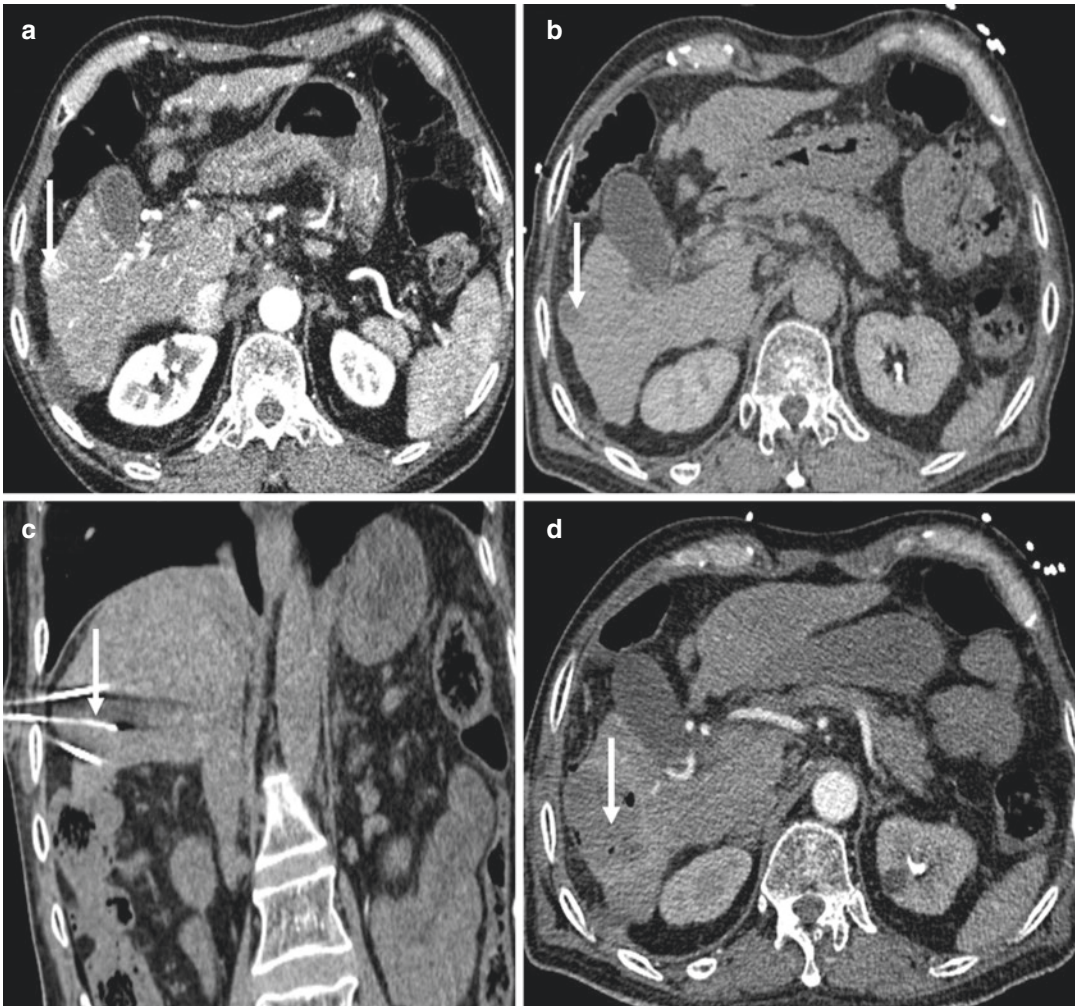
Irreversible electroporation in a 52-year-old male with subcapsular HCC. (a) Arterial phase CT image shows hyperenhancing lesion in segment 5 (arrow). (b)
